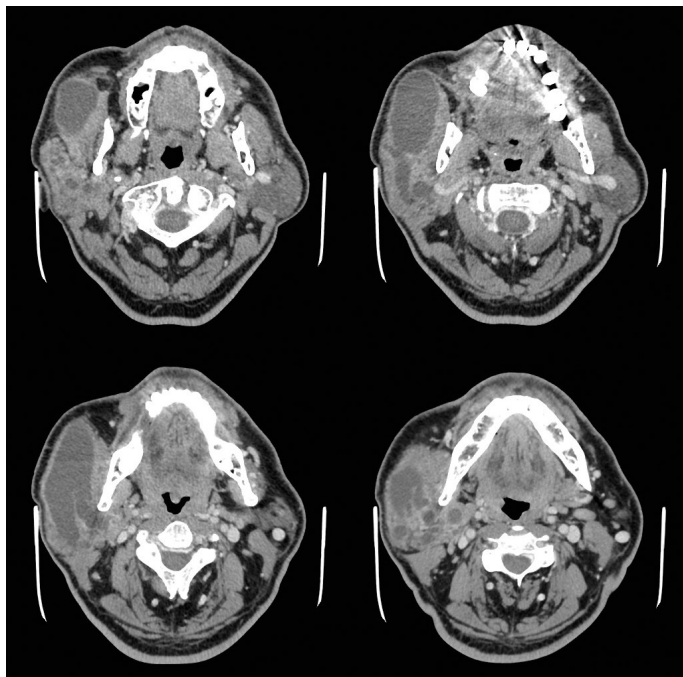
CT scan of the head: Transverse cross-sections reveal multiple sialoceles within the right parotid gland.
